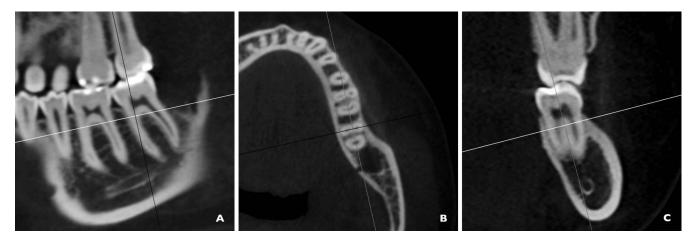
CBCT orientation. (A) Sagittal view. White line: axial plane; Gray line: coronal plane. (B) Axial view. White line: sagittal plane; Gray line: coronal plane. (C) Coronal View. White line: Sagittal plane; Gray line: axial plane.
